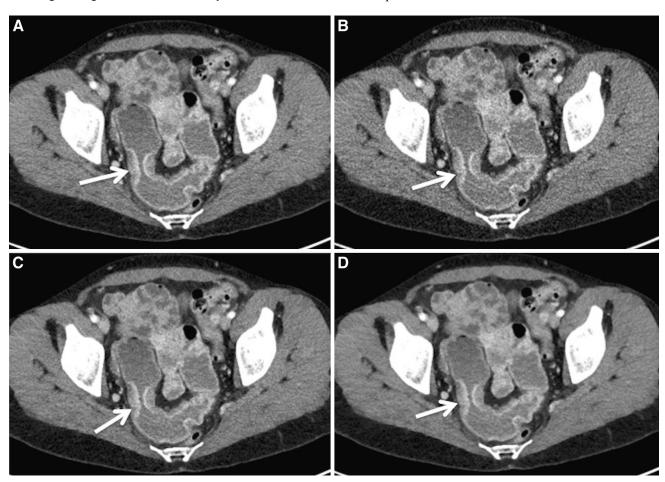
Patient weighing 108 pounds with mixed stenotic and active inflammatory small bowel Crohn's disease of the ileum scanned using CARE kV at full and half-dose, and reconstructed with filtered back projection (FBP) and iterative reconstruction (sonogram-affirmed iterative reconstruction or SAFIRE). Images at full dose (A), half-dose reconstructed with FBP (B), half-dose reconstructed with SAFIRE, strength 3 (C), and half-dose reconstructed with SAFIRE strength 4 (D). Tube voltage selected was 100 kVp; quality reference mAs was 108. The
